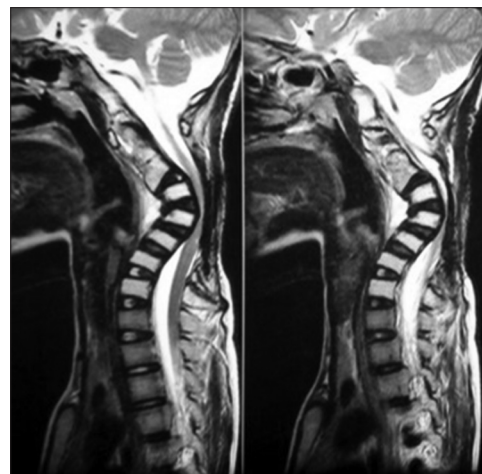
Sagittal magnetic resonance imaging of the patient showing kyphosis
